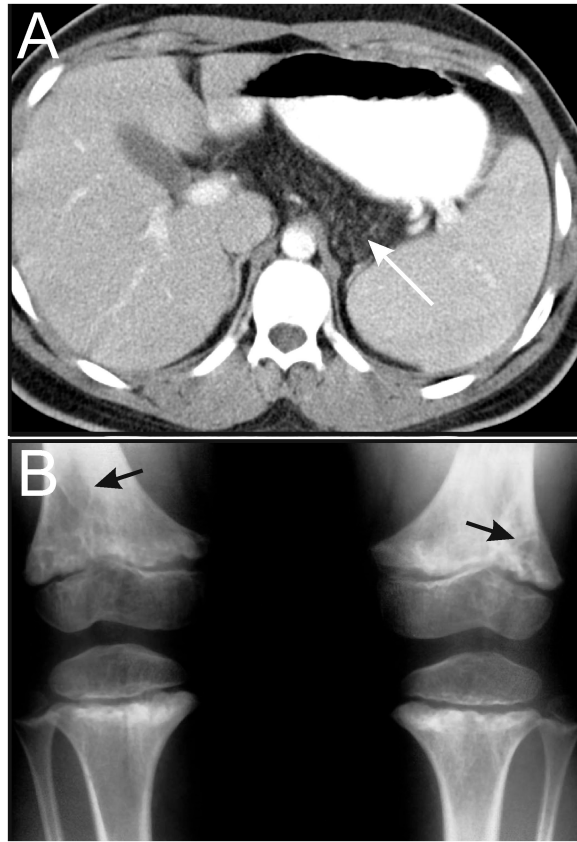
Phenotypic features of SDS. (A) MRI showing fatty infiltration of the pancreas (white arrow). (B) Metaphyseal dysostosis (black arrows). Images courtesy of William H. McAlister, M.D.
